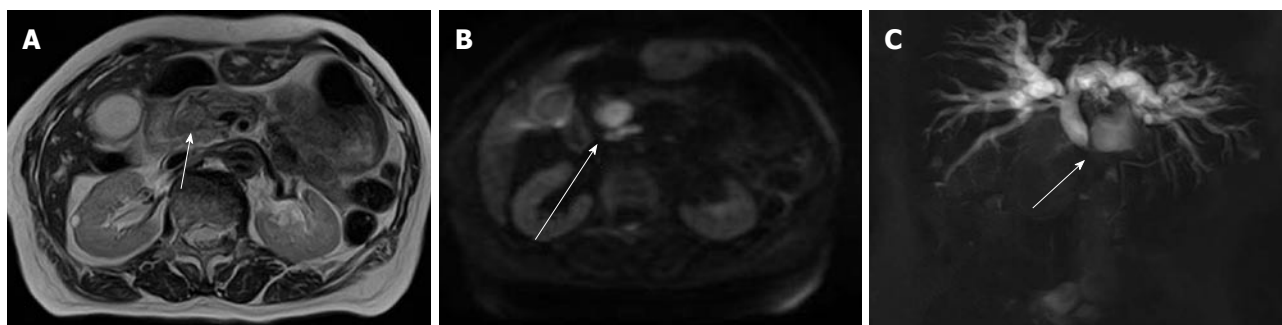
Distal extrahepatic cholangiocarcinoma in an 83-year-old woman. A: Axial T2-weighted image shows wall thickening and slight high mass of the distal common bile duct (arrow); B: Diffusion-weighted imaging shows high signal intensity in the lesion (arrow); C: Magnetic resonance cholangiopancreatography shows occlusion of the distal common bile duct (arrow).
